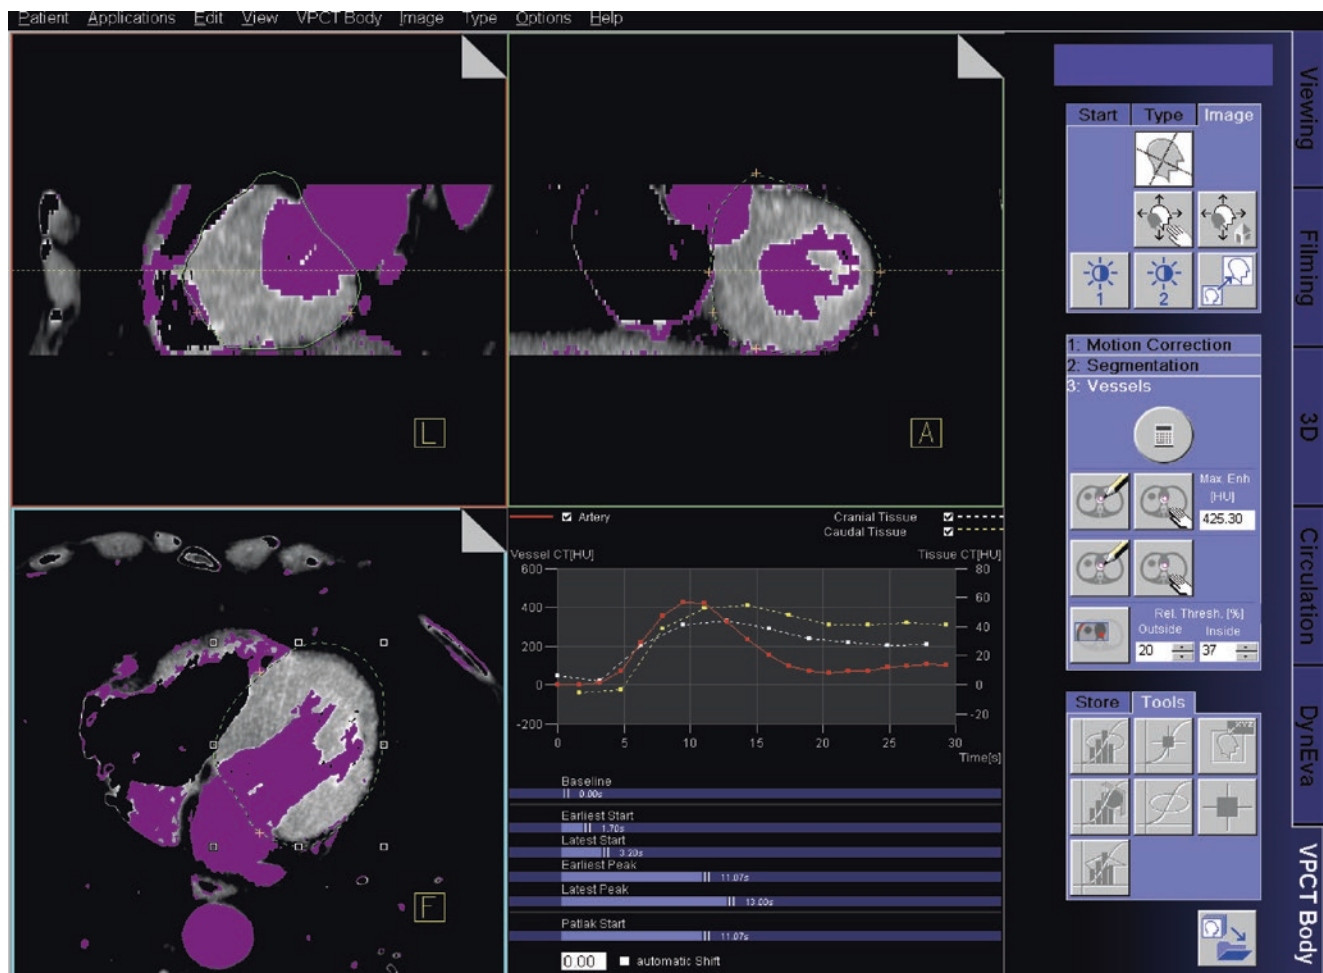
An overview of the Volume Perfusion CT (VPCT) myocardium software (MMWP VA41A, Siemens). Multiple windows allow to visualize different CT axis, show the signal intensity curves for the drawn regions of interest and give corresponding quantitative results
